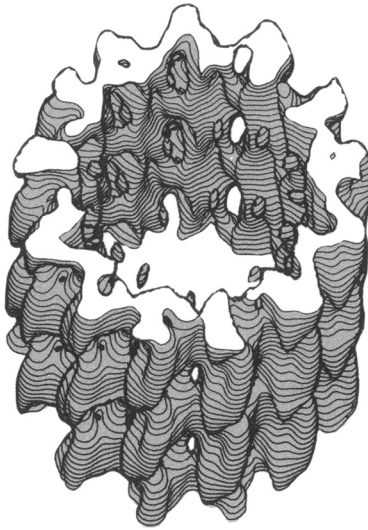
The 1.8 nm resolution X-ray structure of a microtubule. Reproduced from D. Voet and J. G. Voet, *Biochemistry*, Wiley, 1995, with permission
